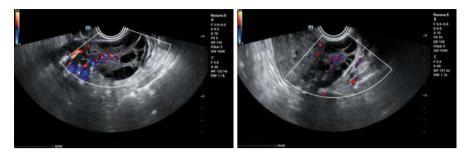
Gray-scale ultrasound reveals polycystic changes in the ovary, while color Doppler ultrasound detects blood vessels running through the ovarian medulla
